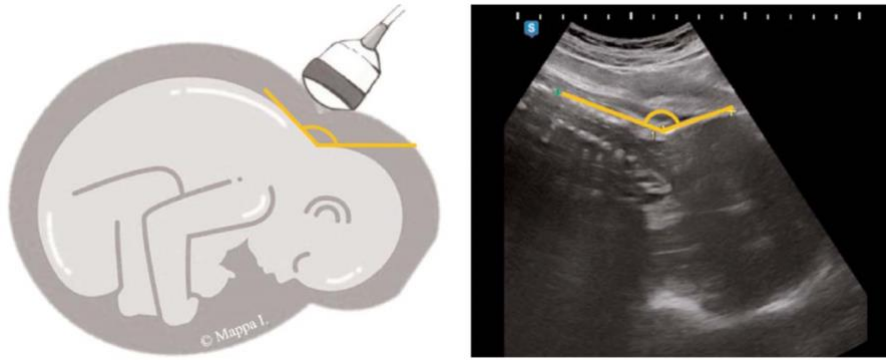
Measurement of occiput spine angle and corresponding ultrasound image (Adapted from *Ultrasound in labor: clinical practice guideline recommendation by the World Association of Perinatal Medicine (WAPM) and the Perinatal Medicine Foundation (PMF)*)¹
